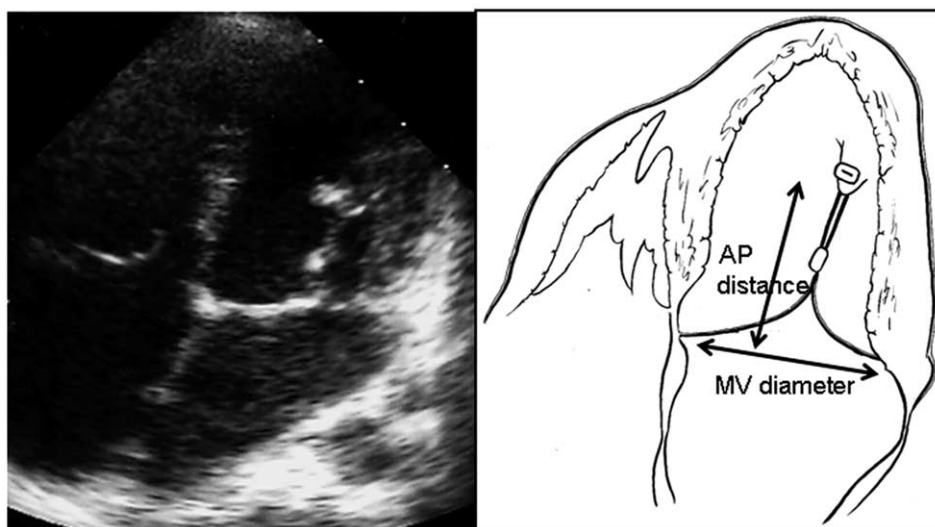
Postoperative echocardiography in 4-chamber view at the end-systolic phase. MV diameter, Diameter of the mitral annulus; AP distance, distance between the mitral annulus and the top of the papillary muscle.
